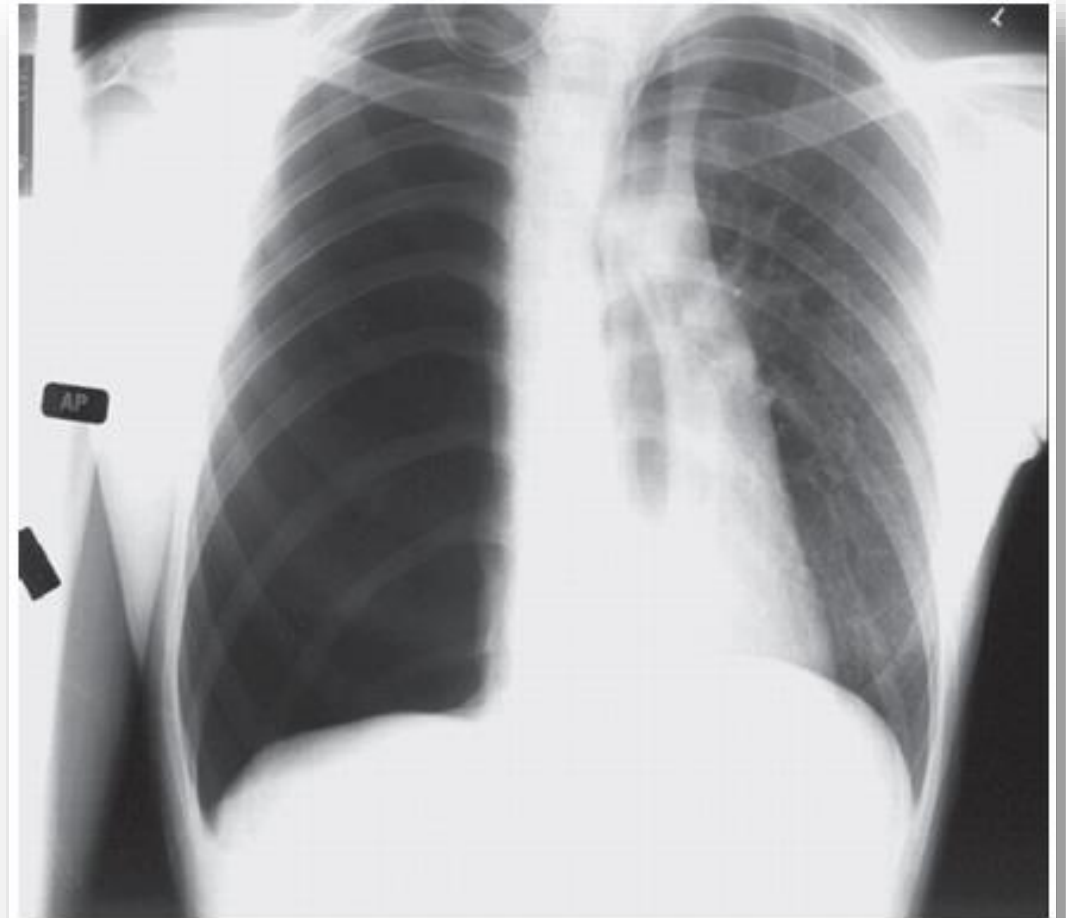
Radiograph showing a right tension pneumothorax with tracheal deviation to the left (courtesy of Professor Stephen Eustace, Dublin, Ireland).
